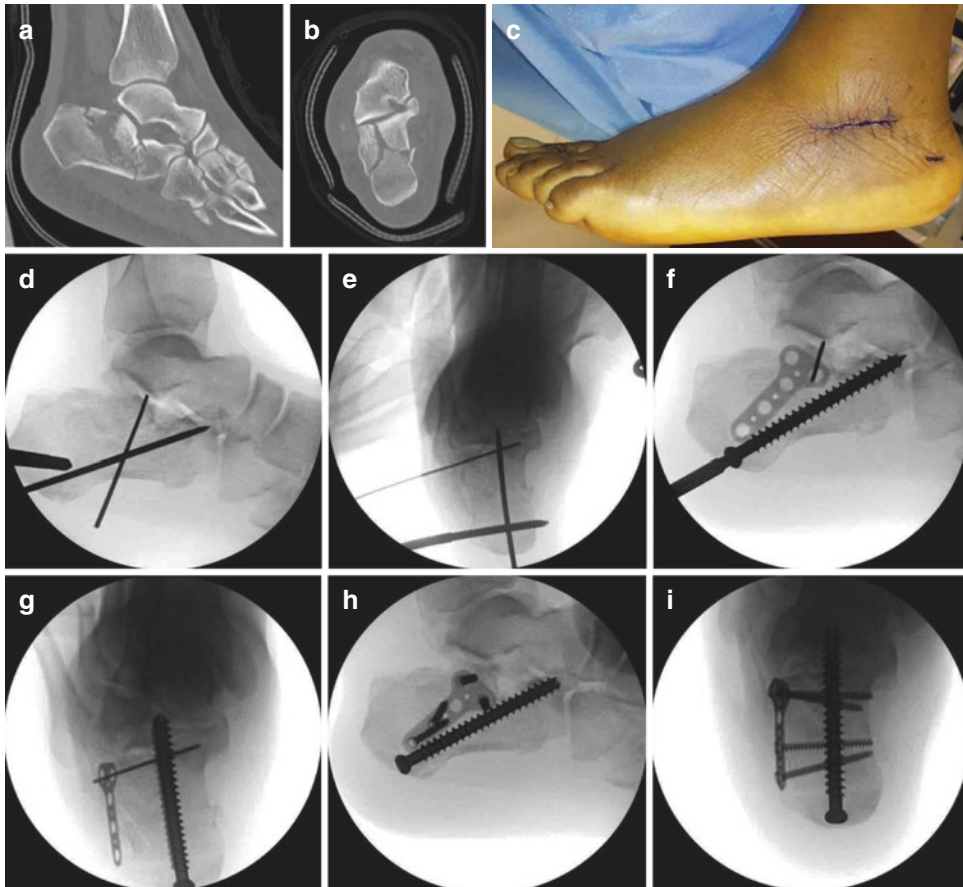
Preoperative (a) sagittal and (b) coronal CT images of the left calcaneus in a 33-year-old male laborer with a Sanders IIB displaced intra-articular calcaneus fracture after a fall from a 10 ft ladder. (c) Clinical photograph demonstrating planned incisions for the sinus tarsi approach and Schanz pin insertion into the posteroinferior aspect of the calcaneal tuberosity. Intraoperative (d) lateral and (e) axial radiographs of the heel demonstrating provisional fixation of the posterior facet fragment into the sustentaculum with a 1.6-mm Kirschner wire after reduction along with guidewire placement for a large cannulated screw from the posterior tuberosity into the anterior aspect of the calcaneus. (f) Lateral and (g) axial radiographs of the heel demonstrating insertion of a large
